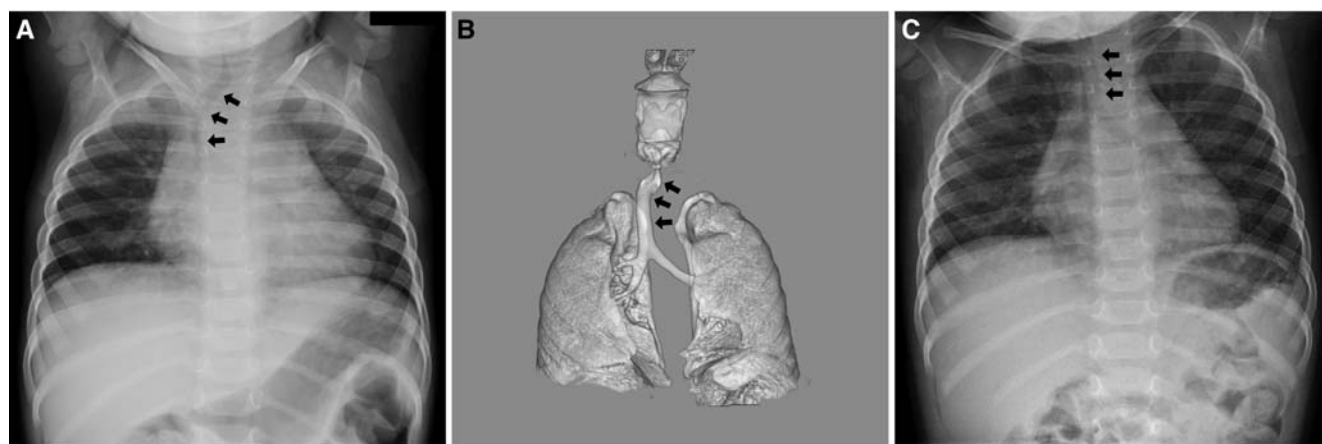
A, Chest radiography showing flexion of the trachea to the right side (arrows). B, Three-dimensional chest CT scan showing flexion of the trachea to the right side, but no vessels or masses compressing and draining the trachea (arrows). C, Second chest radiography at rest showing no flexion of the trachea (arrows).
